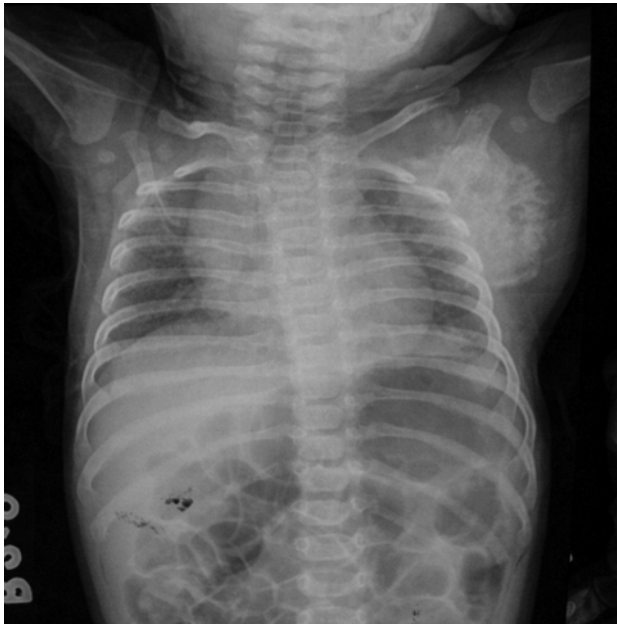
Anteroposterior radiograph of the right shoulder showing obvious destruction of the glenoid and the lateral border of the scapula with normal humeral head.
